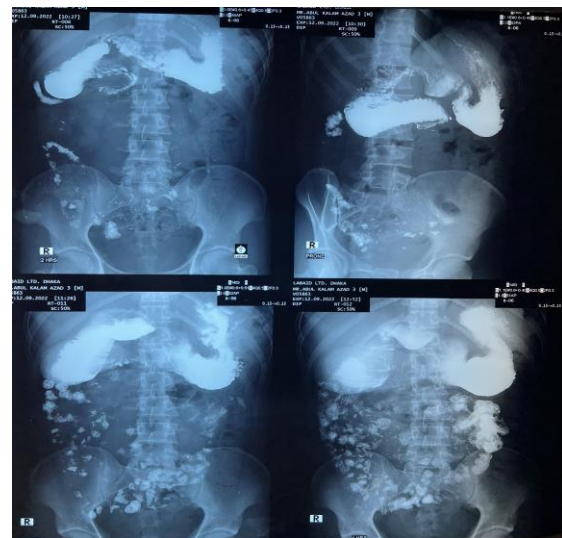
Barium follow through x-ray revealed suggestive of stricture at 3rd part of duodenum with malrotation of gut.
